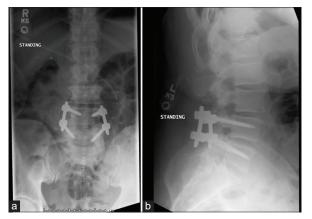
(a) Standing lumbar spine AP X-ray showing good hardware placement. (b) Lateral standing plain film showing preserved sagittal alignment.
